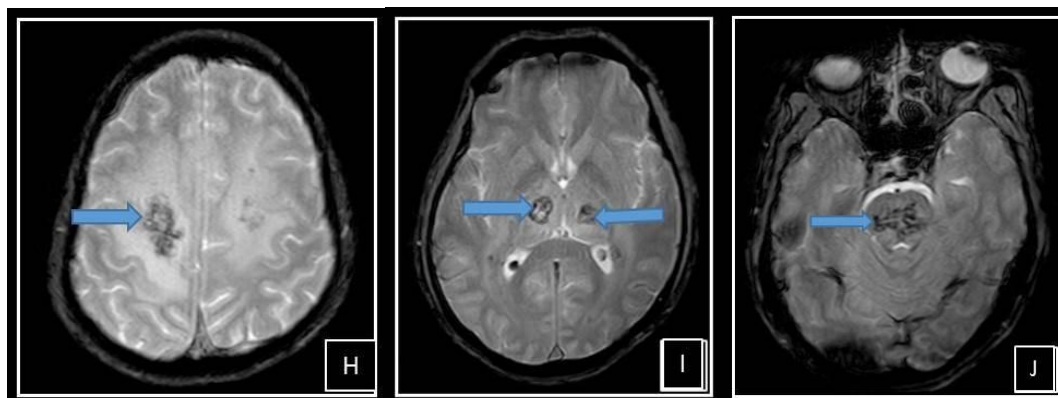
Dengue Encephalitis H, I, J: FFE (GRE) H, I, J: Blooming (blue arrows) in the hyperintensities shown in A, B, C, D (FLAIR images) of figure 3, suggestive of haemorrhage.
